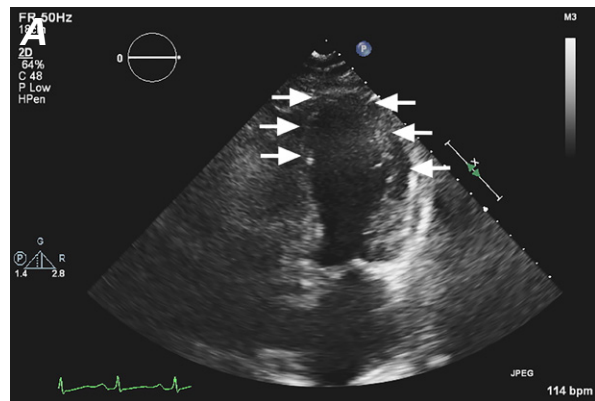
Systolic frames (4-chamber echocardiographic views) show A) hyperkinetic basal segments with akinesis of the left ventricular apical segments upon initial presentation, B) normalization of apical wall motion after 2 months of therapy for thyroid disease and cardiomyopathy, and C) recurrence of those wall-motion abnormalities with relapse of hyperthyroidism. Arrows highlight the poor contractility of the mid-to-apical segments typical of takotsubo cardiomyopathy.
